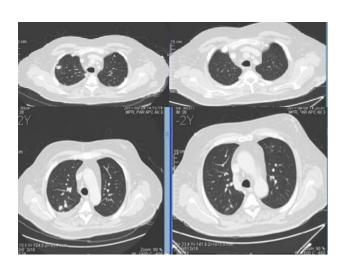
a CT scan showed a significant pulmonary response
